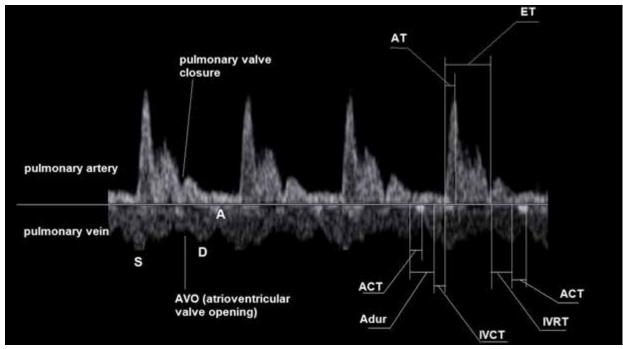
Doppler spectrum of blood flow in the pulmonary artery (above the isoline) and pulmonary vein (below the isoline)
